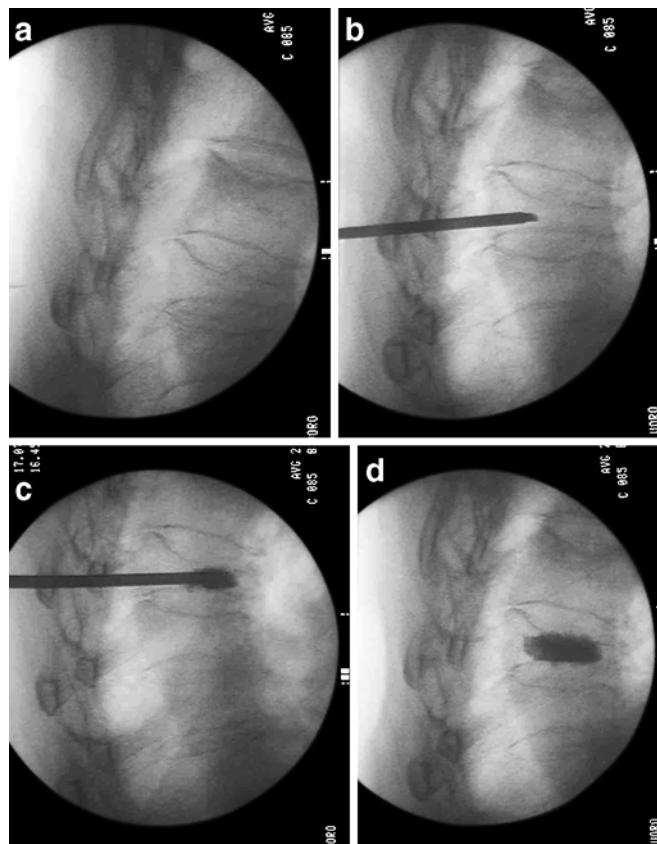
a Localization of an osteoporotic fracture under fluoroscopic control (lateral view). Note the vertebral collapse b Transpedicular positioning of an 11-gauge needle into the vertebral body under fluoroscopic control (lateral view) c Injection of bone cement under fluoroscopic control (lateral view) d Control radiograph shows satisfactory filling of the vertebral body
